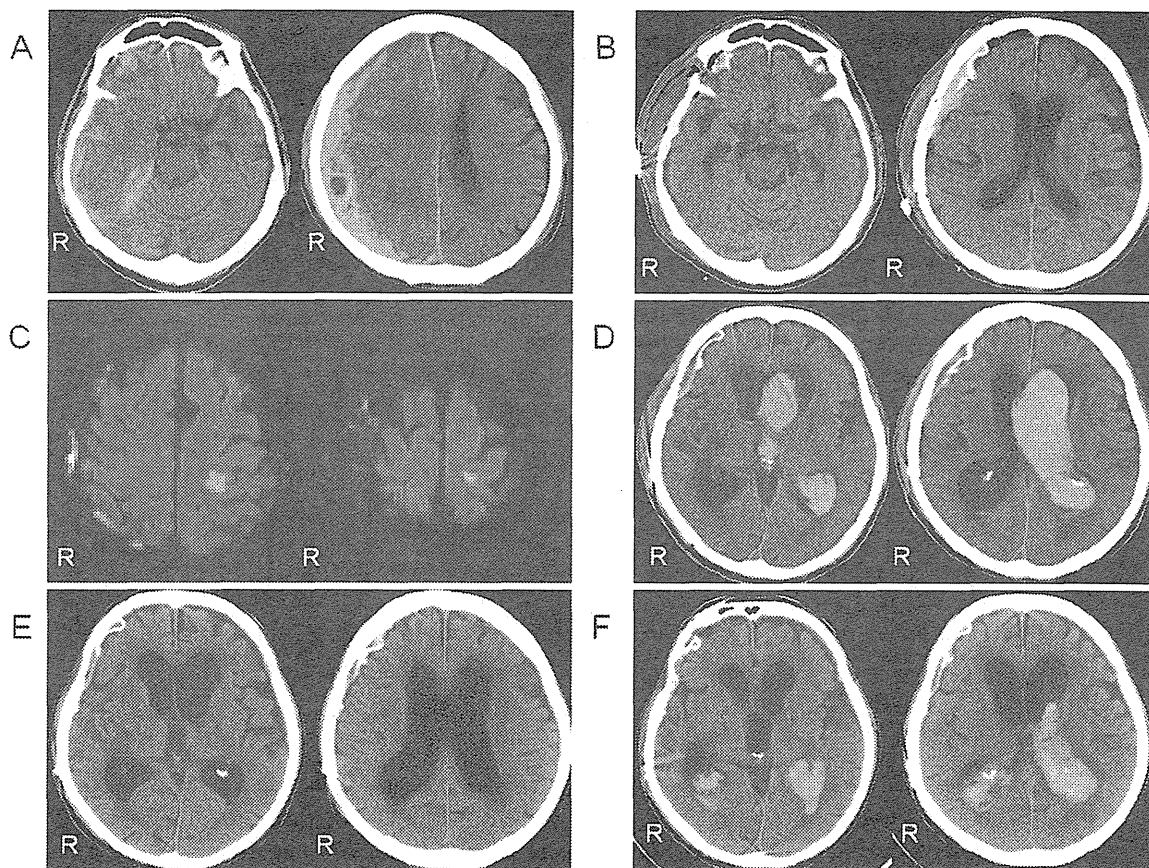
Head computed tomography (CT) and head magnetic resonance imaging (MRI) during hospitalization. (A) Head CT on admission revealed an acute subdural hematoma and brain contusion in the right frontal lobe. (B) Head CT on day 36, the day following cranioplasty, showed that the intracranial hemorrhage did not recur. (C) Head diffusion-weighted MRI on day 51 revealed an acute brain infarction. (D) Head CT on day 61 revealed an intraventricular hemorrhage with hydrocephalus. (E) The intraventricular hemorrhage improved by day 120. (F) However, the intraventricular hemorrhage recurred at day 137.
